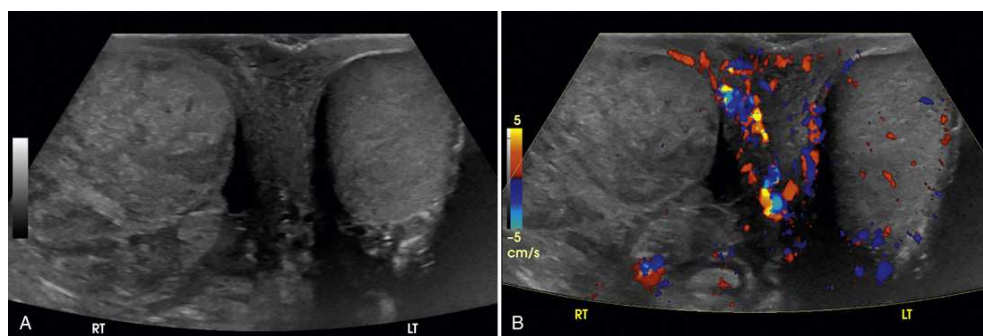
Bilateral midline transverse images of testicles. Testicular torsion, right side. (A) Ultrasound image showing enlarged right testicle and patchy echogenicity (note homogeneous echogenicity of normal left testicle). (B) Color Doppler in same patient, same plane. Note lack of color in right testicle. Evidence of torsion. Courtesy Nisa Hinklin, RT[R], RDMS[AB], NEA Baptist Memorial Hospital, Jonesboro, AR.
